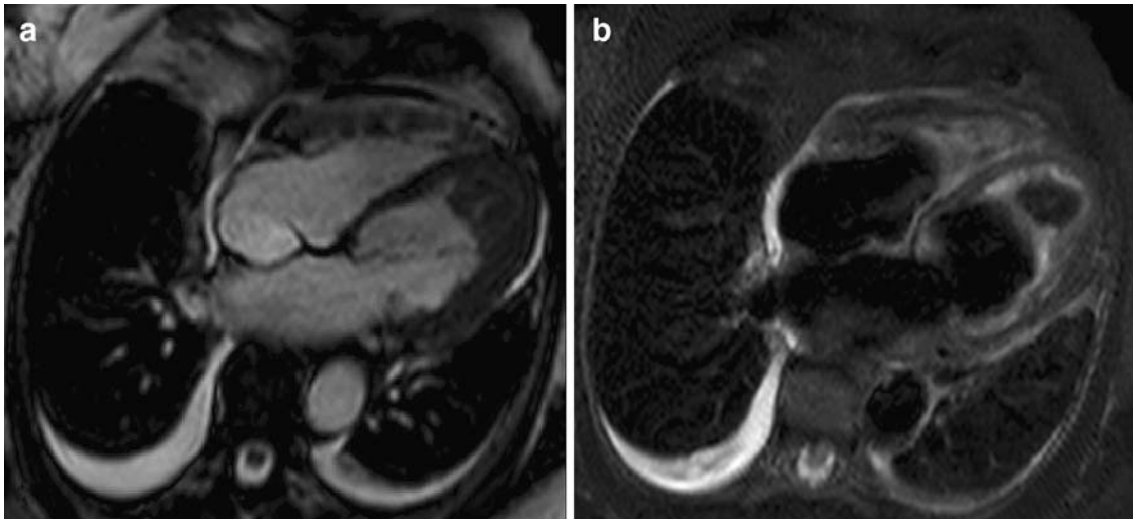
Transverse T2-weighted (a) and black-blood fat-saturated T2-weighted (b) images. Increased T2 signal at the endocardial rim is evident between apical hypointense thrombus formation and myocardium. Also bilateral pleural and minimal pericardial effusion can be seen.
